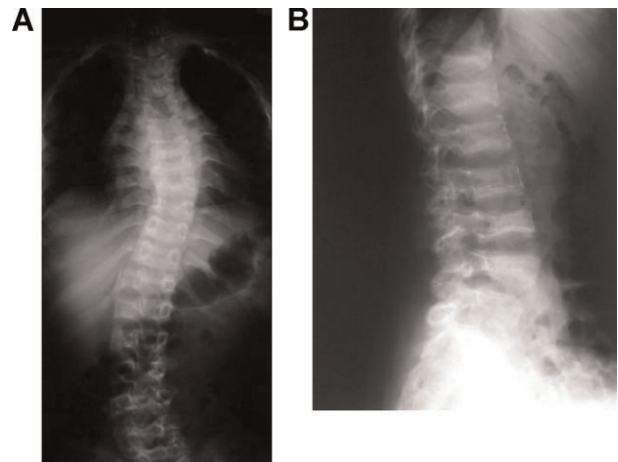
Spinal radiographs at 11 years. Note the osteopenia and compression of several vertebral bodies which are concave and wedge-shaped.
